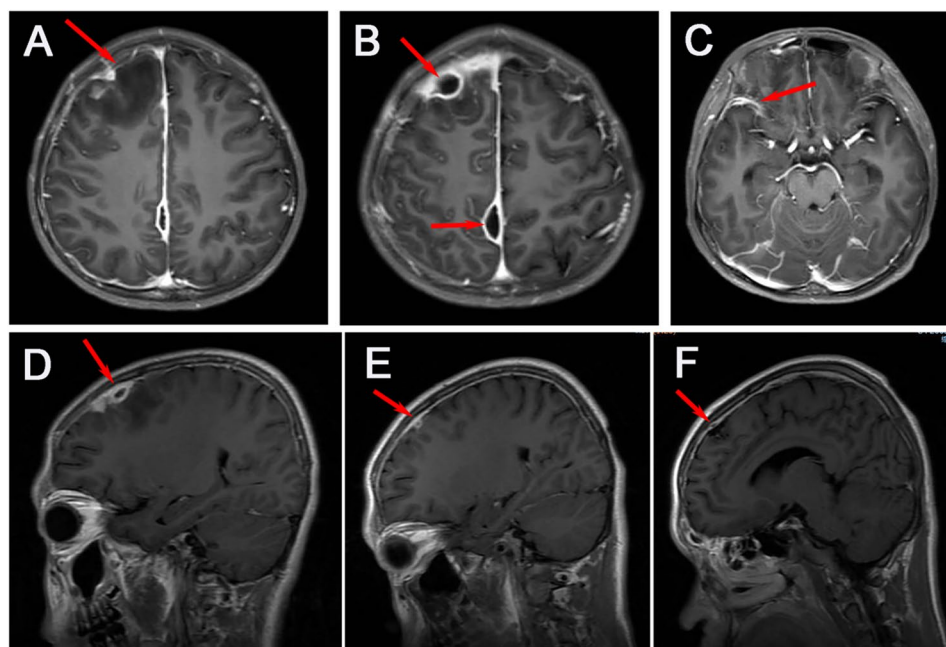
The changes of intracranial lesions by enhanced MRI. A-C revealed pachymeningeal and parenchymal enhancement of right frontal lobe (A), localized subdural empyema of the right frontal part (12 mm×8.5 mm) and right side of cerebral falx (15 mm×6.5 mm, B), and obvious meningeal enhancement (C) in the 17th day. D-F revealed the improvement of intracranial lesions in the 30th day (D), 64th day (E), and 95th day (F)
